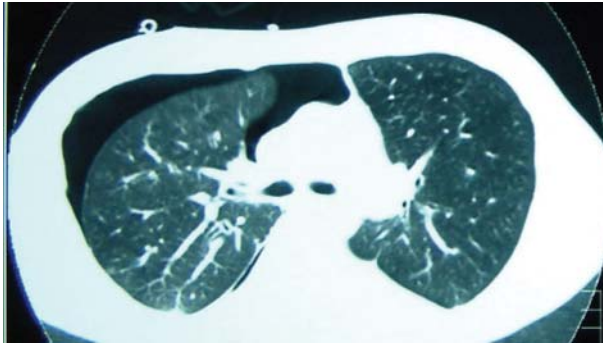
CT chest. Lung windows showing right sided pneumothorax, and mucus plugging with centrilobular nodular appearance.
